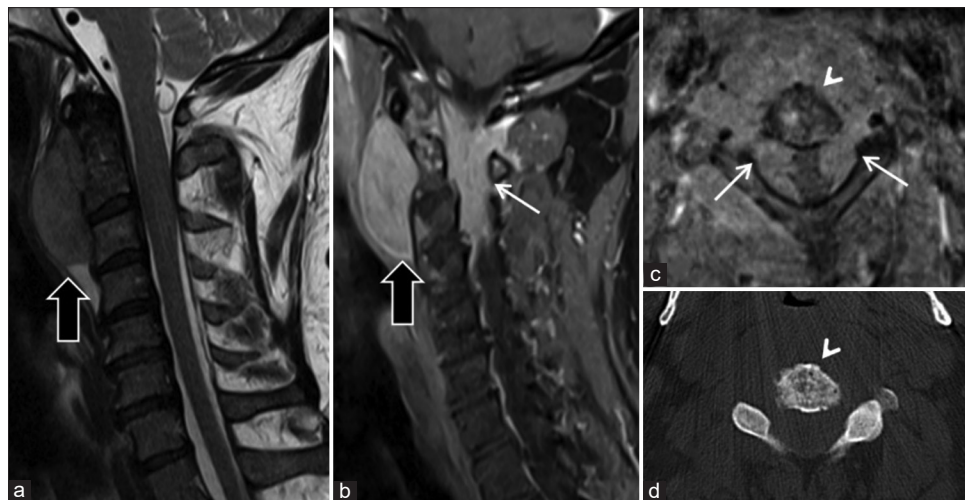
Prevertebral diffuse large B cell lymphoma in a 58-year-old male. Sagittal T2 (a) and T1 with fat saturation after IV gadolinium administration (b) showed large ovoid T2 hyperintense, enhancing mass within the prevertebral space (black arrows). Abnormal bone marrow enhancement of C2 vertebral body, suspicious for osseous origin or infiltration by the soft-tissue mass. Sagittal T1 with fat saturation after IV gadolinium administration also showed significant intraspinal extension with large enhancing mass compressing the spinal cord (white arrow). Axial T1 with fat saturation after IV gadolinium administration (c), and high-resolution non-contrast CT in bone window at the same level (d) confirmed the osseous erosive changes (arrow heads), and large enhancing intraspinal component (white arrows).
